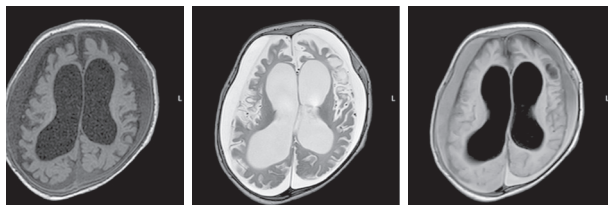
Magnetic resonance imaging of a patient at the age of 4 months. Axial sections, T1 VI, T2 VI, Flair. There is a negative dynamics in the form of cystic-atrophic changes in the large hemispheres of the brain with the formation of atrophic hydrocephalus. The appearance of symmetrical subshell clusters in the form of subdural hygromas
